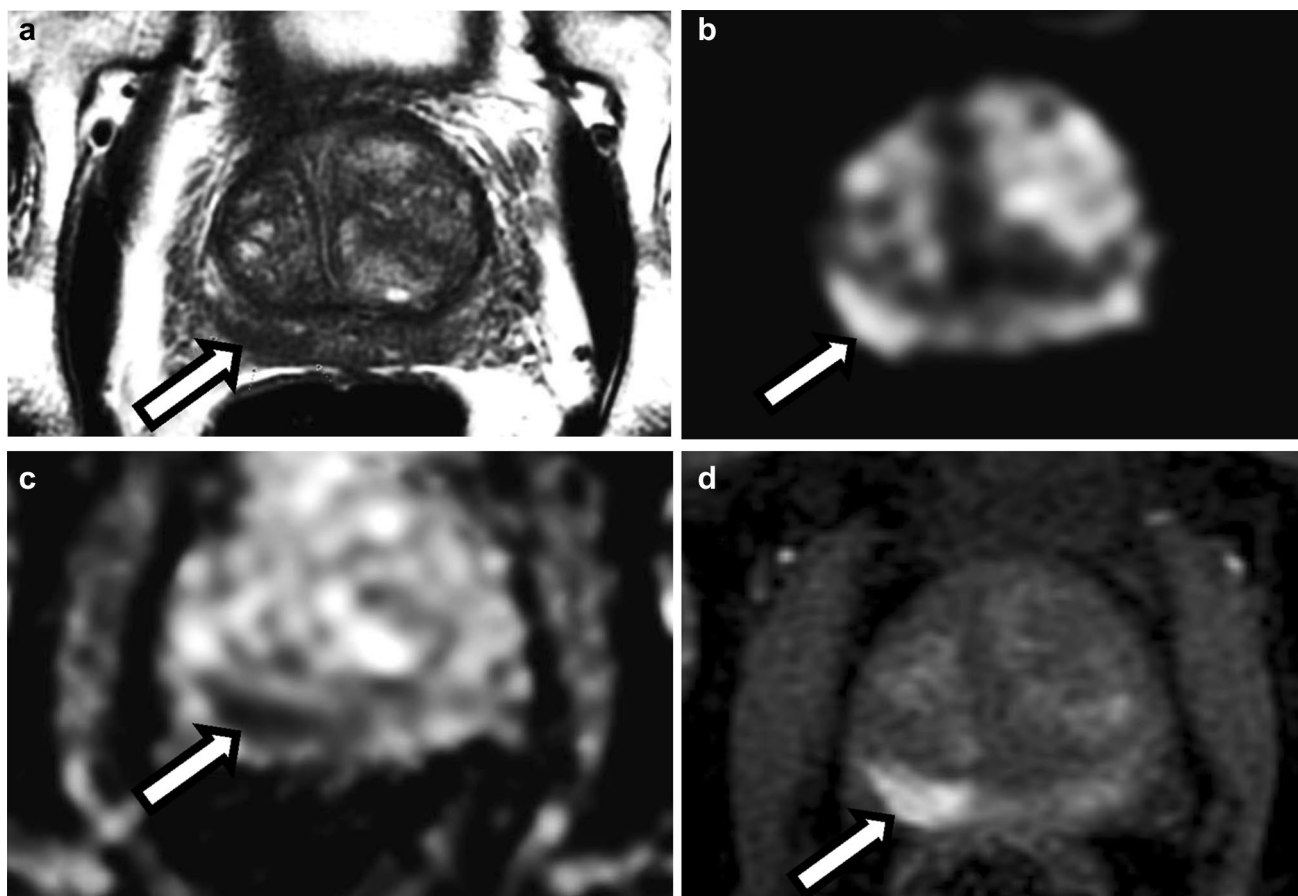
A 69-year-old with PSA of 10 ng/ml and TRUS Biopsy showing Gleason 3 + 4 = 7 cancer on the right. Multi-parametric MRI (mpMRI) was performed due to rising PSA. mpMRI demonstrates a PI-RADS 5 lesion in the right posterior peripheral zone in the base
